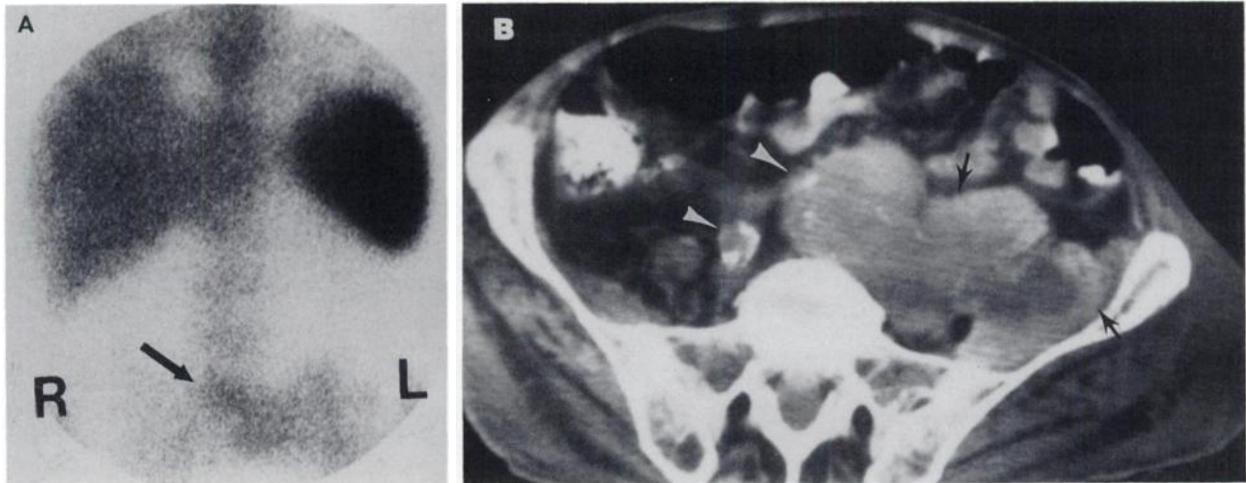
A 72-yr-old man (Patient 3) with peripheral vascular disease, fever, positive blood cultures and a sacral decubitus ulcer. (A) WBC scan shows a large focus in the mid and left pelvis (arrow). (B) CT scan (without intravenously administered contrast material) shows a calcified aorta, iliac arteries (arrowheads) and a 8 × 13-cm soft-tissue mass in the left iliac region (arrows). A mycotic aneurysm of the left common iliac artery surrounded by a large abscess was found at surgery.
